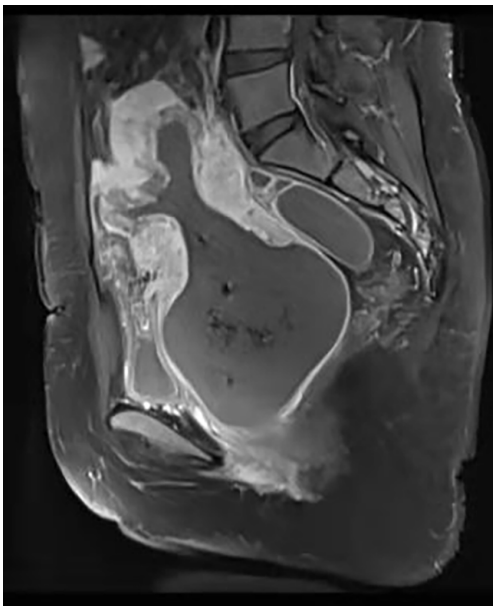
MRI demonstrating a large mass and incomplete uterine inversion. MRI, magnetic resonance imaging.
